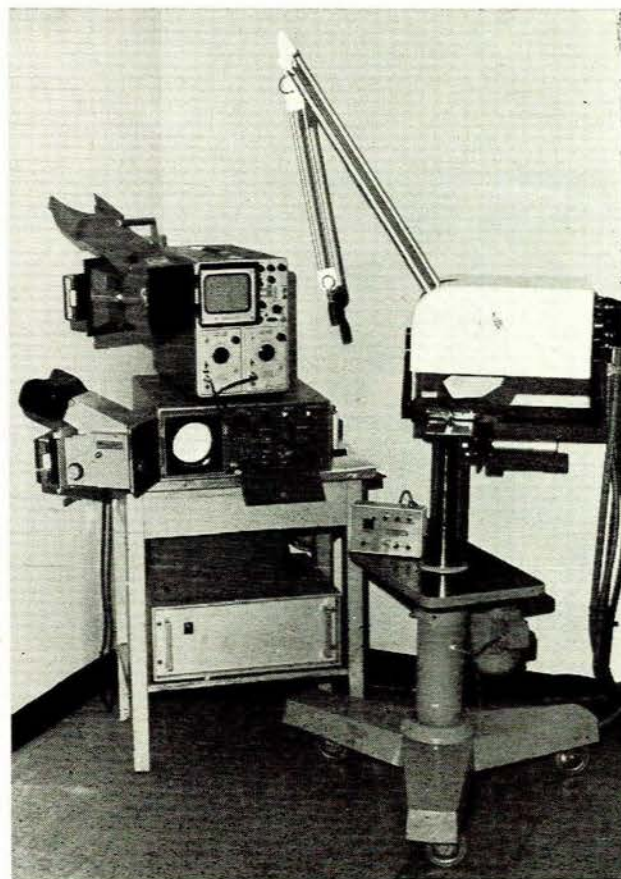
The Ekoline 20 Diagnostic Ultrasonoscope used in this study.
